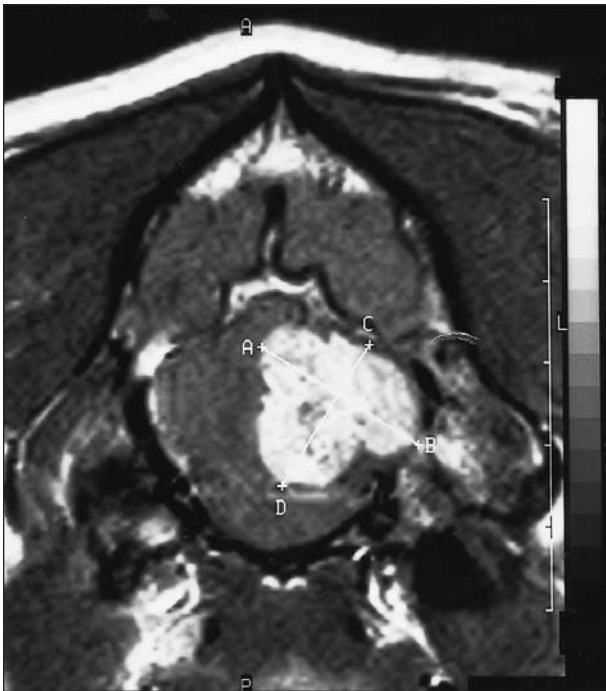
T1-weighted, transverse magnetic resonance image (MRI) through the brain at the level that includes the caudal lobe of the cerebellum. Notice the extent of the cerebellar mass (23.6 mm X 20.7 mm).
